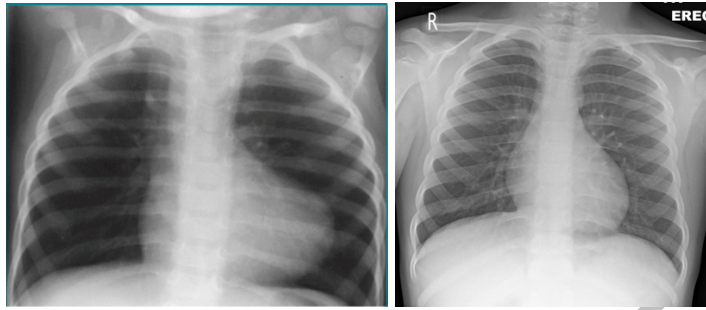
Traditional Chest X-Ray displaying the boot-shaped heart sign associated with Tetralogy of Fallot (Left). The upward pointing cardiac apex and narrowed pulmonary artery is not present under normal conditions (right).
